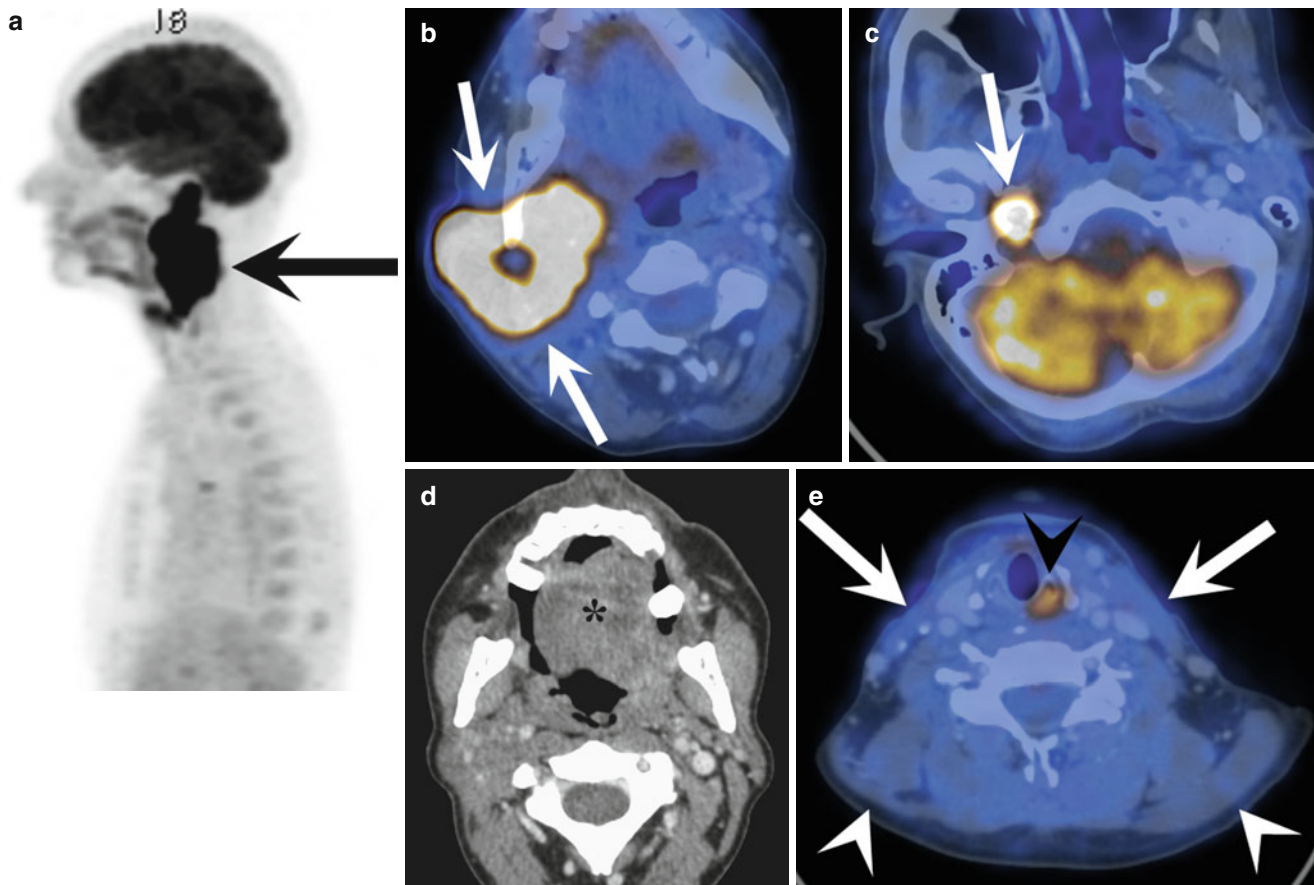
Patient with cervical lymph node metastasis from an unknown primary tumor. Sagittal FDG-PET maximum intensity projection (MIP) image (a) shows an FDG-avid mass (*arrow*) in the neck, extending from the skull base to the level of the hyoid. The centrally necrotic mass (*arrows*) involves the parapharyngeal space, masticator space, and subcutaneous tissue on the right side, as seen on axial contrast-enhanced FDG-PET/CT image (b). The top of the mass (c, *arrow*) resides below the skull base at the level of the jugular foramen, which is infiltrated.
